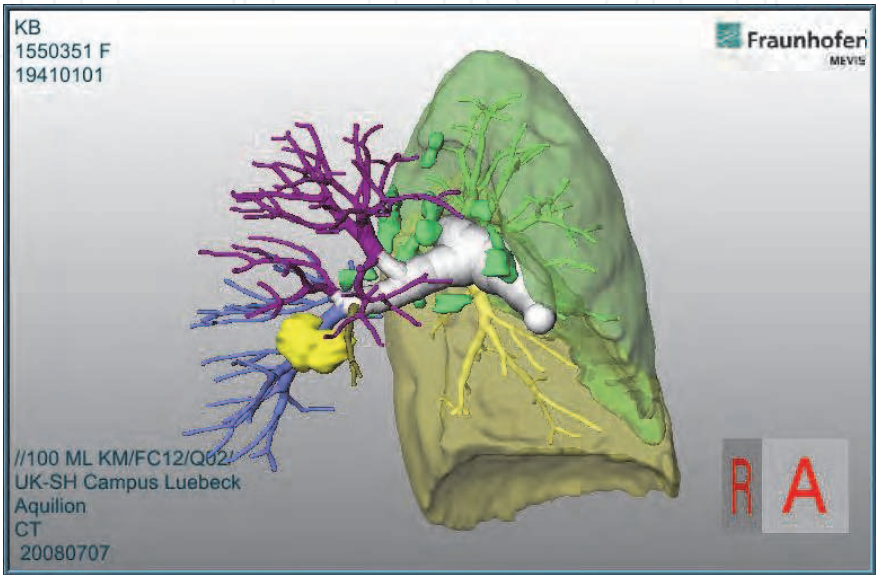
67-year-old patient with a suspected local relapse of an adenocarcinoma in the right lower lobe. Status post primary transthoracic radiation therapy with initial functional inoperability (tumor highlighted in yellow).
